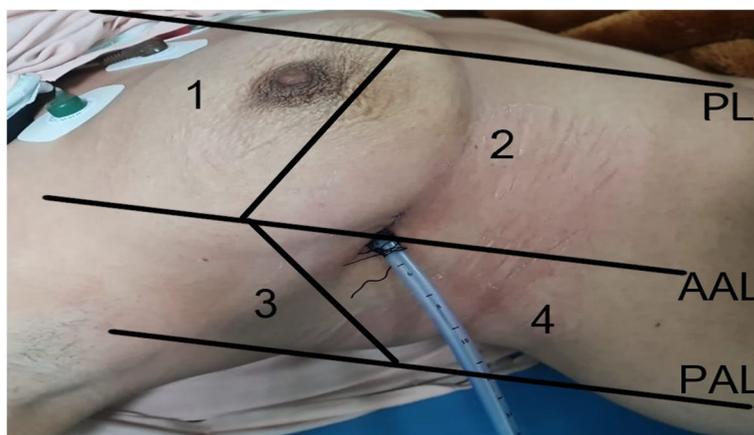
PL: parasternal line. AAL: anterior axillary line; PAL: posterior axillary line. 1 Anterosuperior area. 2 Anteroinferior area. 3 Lateral superior area. 4 Lateral inferior area
